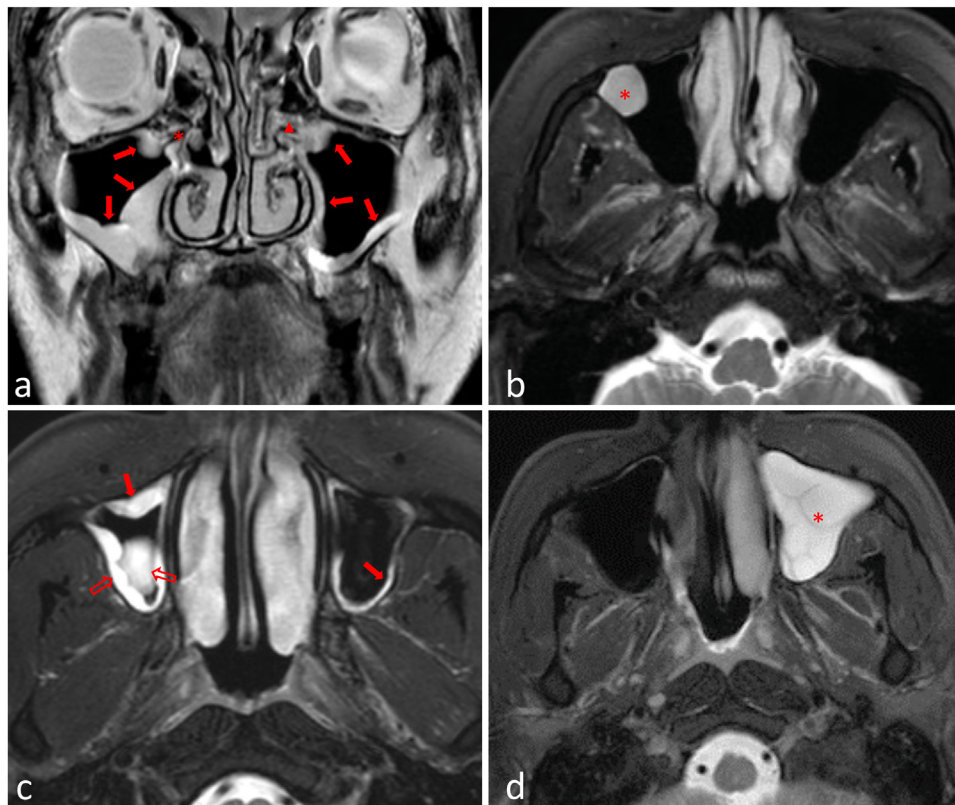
Representative T2-weighted MR images on the coronal (a) and axial (b-d) planes demonstrating various mucosal morphological thickening in the maxillary sinus: flat or irregular thickening >2 mm on the lateral, inferior, medial, superior, and/or posterior walls (solid arrows in a and c), semispherical thickening on the lateral and posterior walls (asterisk in b), mixed flat and semispherical thickening (hollow arrow in c), and complete opacification (asterisk in d); and patent (asterisk in a) or obstructed (triangle in a) primary maxillary ostium.
